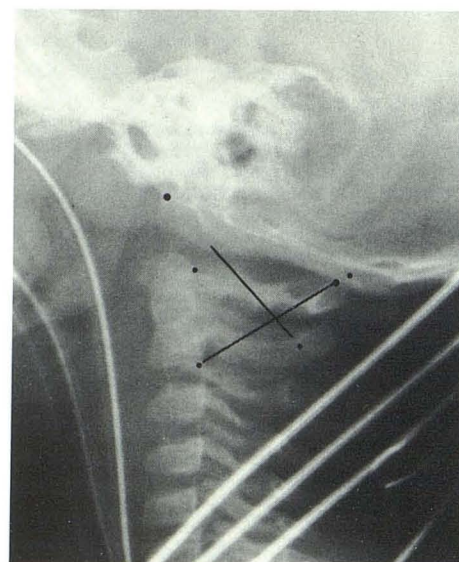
Case 11, 1-year-old boy who had been struck by a car. Although atlantooccipital joint appears widened on radiograph, joint width measured 4 mm, within normal limits. However, the dens-basion line was 15 mm, suggesting atlantooccipital dislocation. In this case, X lines gave a false-negative diagnosis. Diagnosis of dislocation was based more on clinical presentation than on radiographs.
